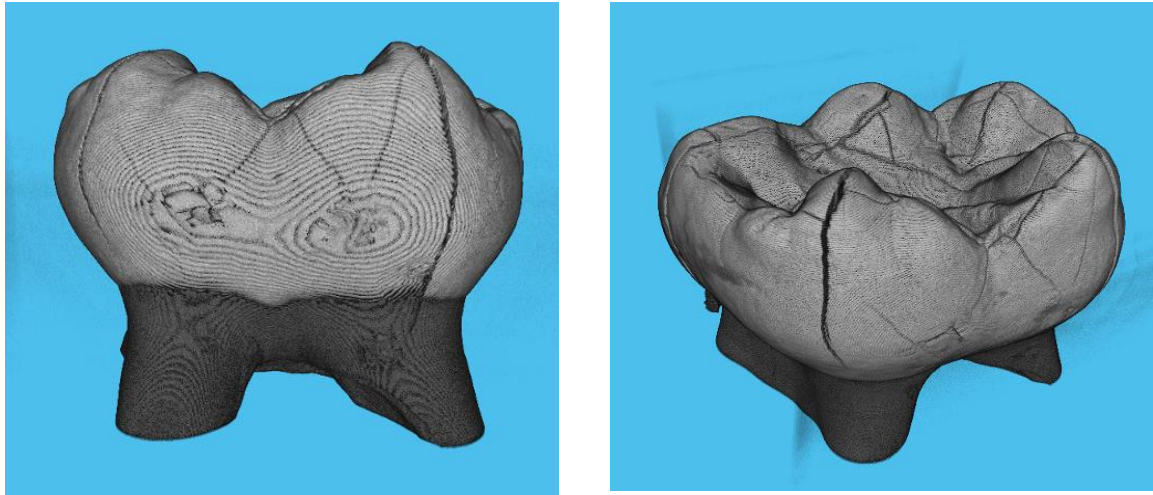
Images captured using X-ray CT
